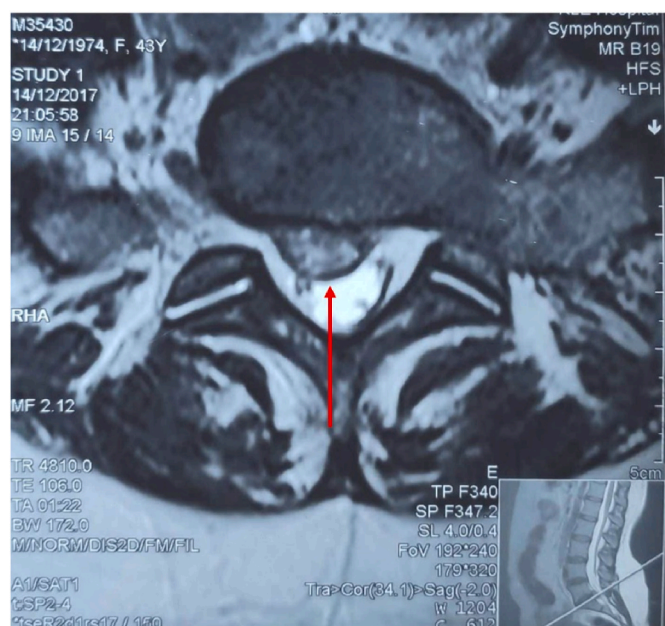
The red arrow in axial T2-weighted image shows the exact extent of compression over the subarachnoid space and traversing nerve roots by sequestered disc.
